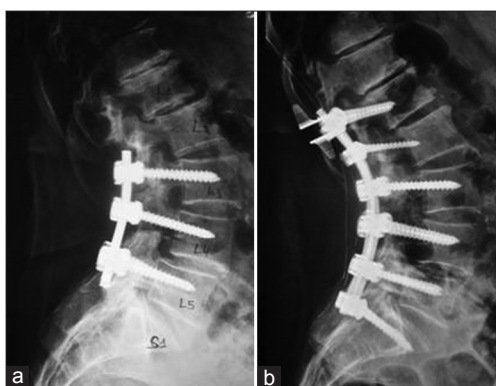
(a) Pre-operative lumbosacral spine X-ray before insertion of interspinous distracter at Th12-L1 level showing a degenerated disc at a level superior to the one necessitating posterior rigid fusion. (b) Post-operative lumbosacral spine X-ray after insertion of ISD at Th12-L1 level showing a degenerated disc at a level superior to the one necessitating posterior rigid fusion
